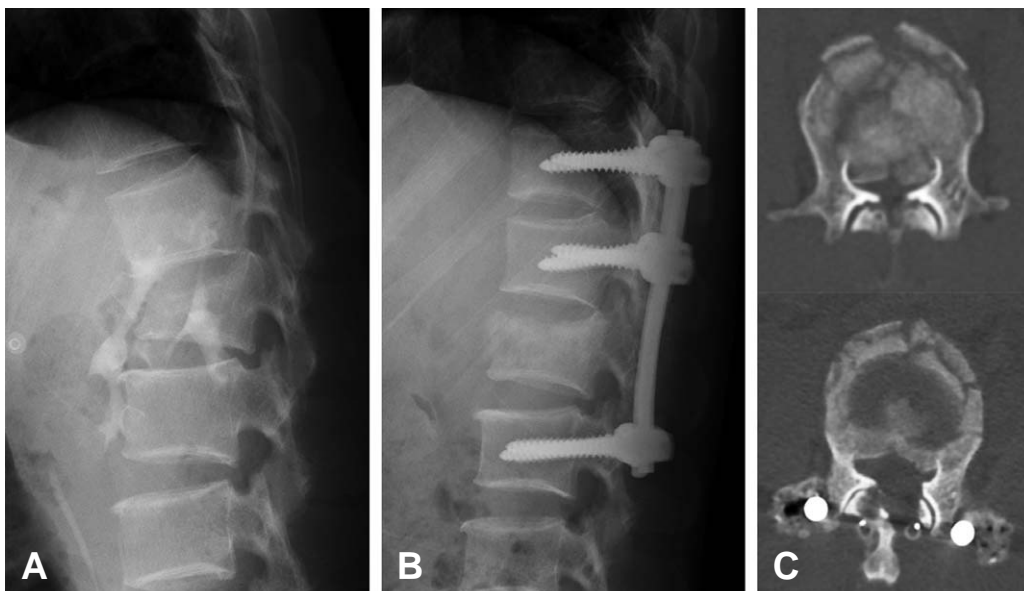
A 41-year-old man with AO type B and incomplete neurologic deficit. (A) Lateral radiograph with segmental kyphosis. (B) Postoperative radiograph after posterior surgery. (C) Pre- and postoperative CT axial images shows marked decompression of bony fragment in the spinal canal.
